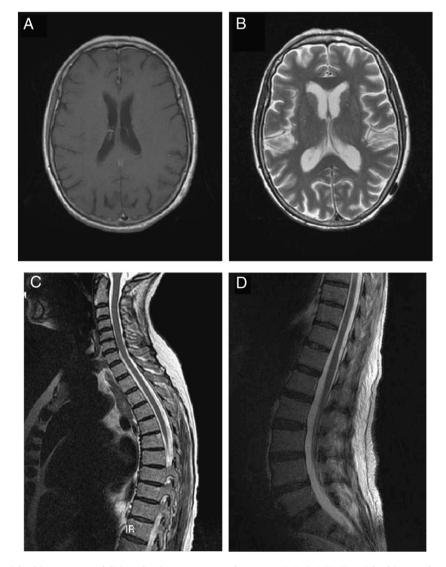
MRI. A. Brain MRI: T1-weighted images post-gadolinium showing no contrast enhancement. B. Brain MRI: T2-weighted images showing patchy, non-specific lesions hyperintense in the subcortical and deep white matter of both cerebral hemispheres C–D. Spinal cord MRI showing no areas of abnormal intensity signal.
